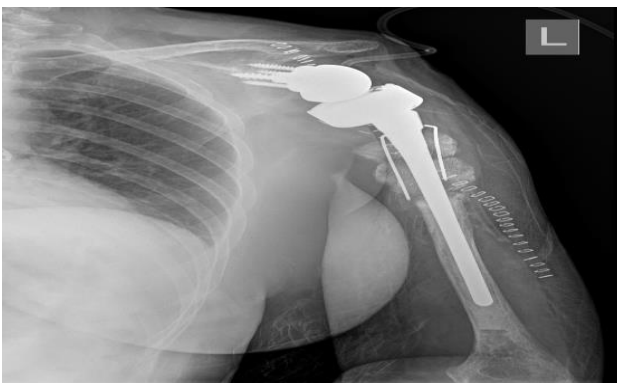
X-ray of left humerus of patient B immediately post resection of the proximal left humerus including the lytic lesion and replacement with cemented reverse total shoulder arthroplasty prosthesis with circumferential allograft bone blocks augmentation around the humeral stem and k-wire fixation of bone blocks.
